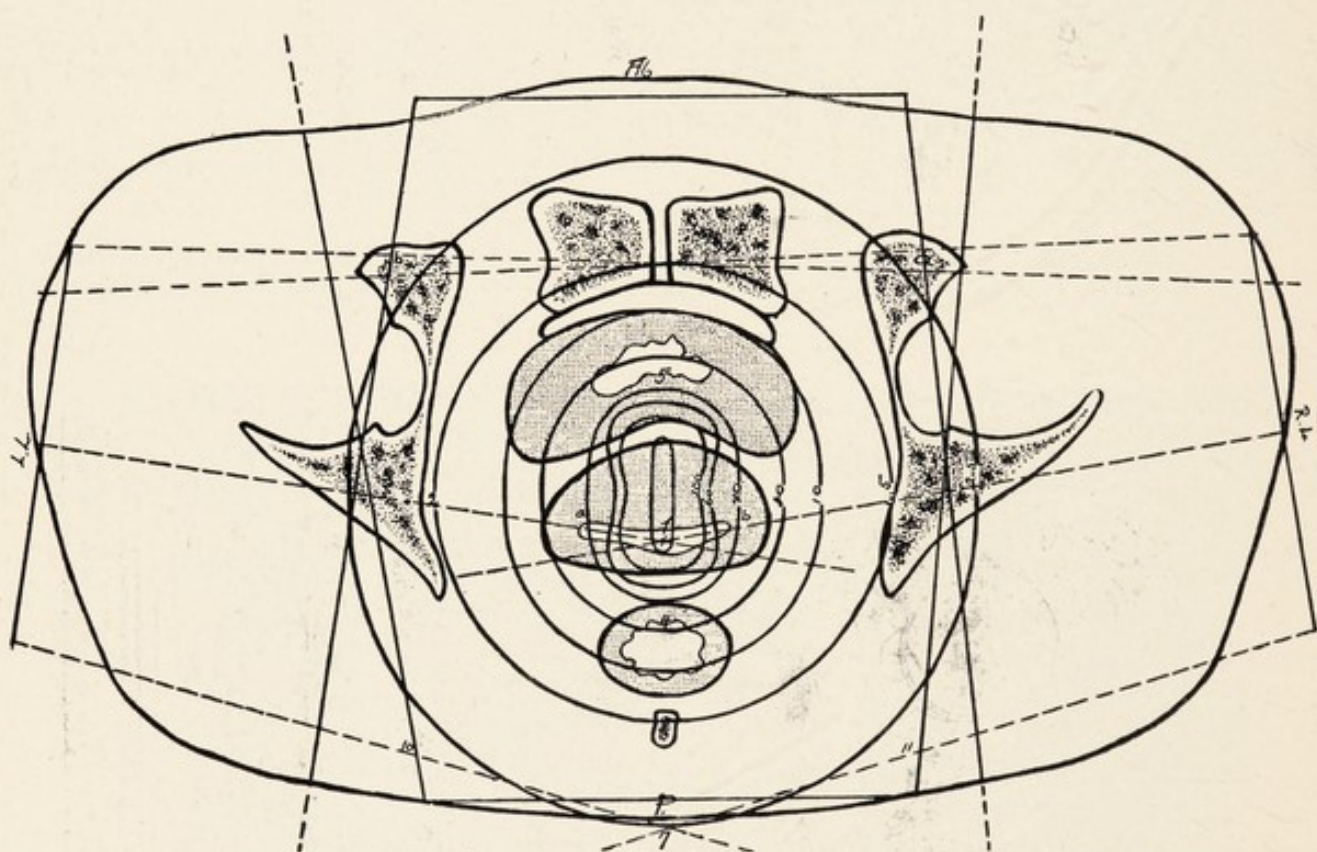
TRANSVERSE SECTION OF A FEMALE PELVIS SHOWING FOUR X-RAY BEAMS MARKED *A*, *P*, *R.L.*, AND *L.L.*, AND POSITION OF RADIUM CAPSULE AND EQUAL INTENSITY CURVES. The calculations of the intensities of X-rays at points 1 to 11 and *a* and *b* are given in the text.
